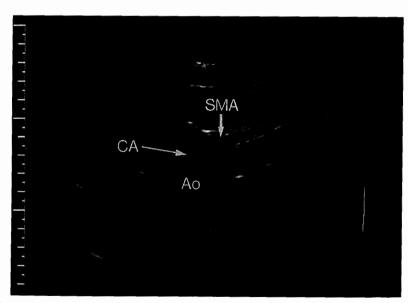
B-mode ultrasonography of splanchnic vessels. SMA = superior mesenteric artery; CA = celiac artery; Ao = aorta.
